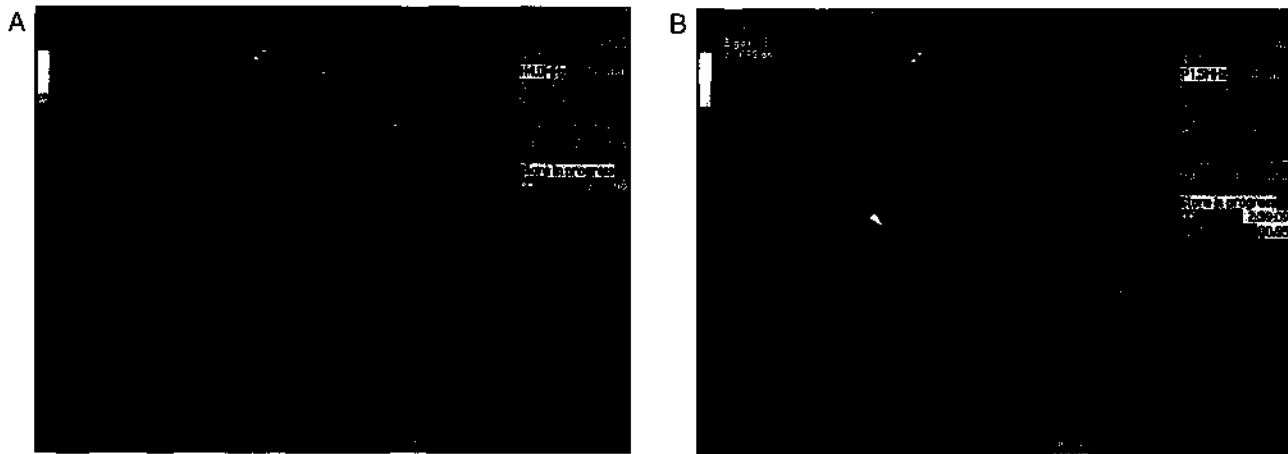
Stab wound of the liver. This patient suffered a penetrating injury to the right liver; despite knowing exactly where to look, it could not be demonstrated on grayscale ultrasound (A). Following administration of a contrast agent (SonoVue, Bracco, Milan), the lesion was clearly shown (arrowhead in B).
